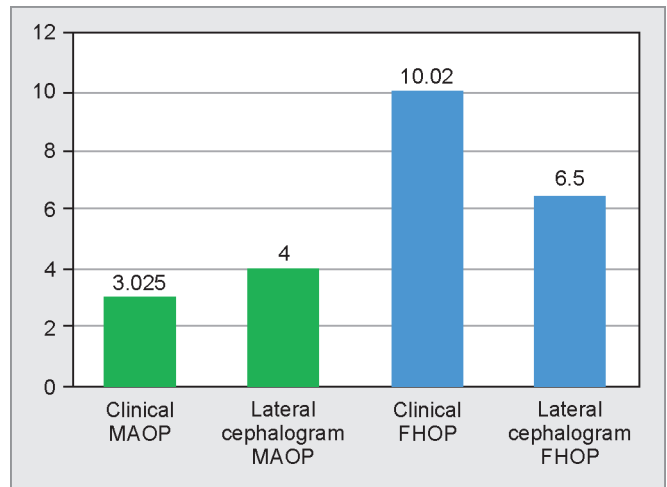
Descriptive values for Camper's plane and occlusal plane (MAOP), Frankfort horizontal plane, and occlusal plane (FHOP) clinically and radiographically
